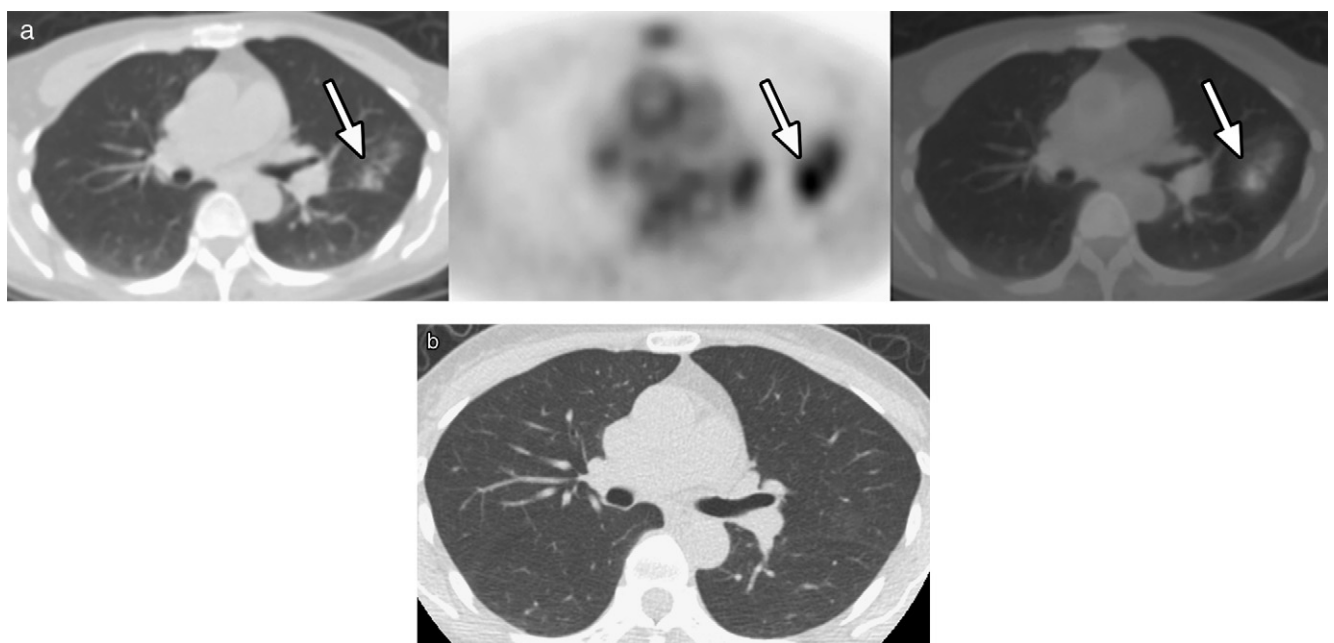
Subject 3's serial radiographic studies. (a) There was faint, tiny  $^{18}\text{F}$ -FDG-avid focus (black arrows) with corresponding CT ground-glass opacity in the left upper lung field on the representative transaxial slices of CT, PET and fused PET/CT after Glscope. The subject did not experience any pulmonary symptom before and after Glscope and there was no CXR abnormality before Glscope (not shown). (b) Resolution of the prior ground-glass opacity was observed on the follow-up chest CT 3 weeks after Glscope.
